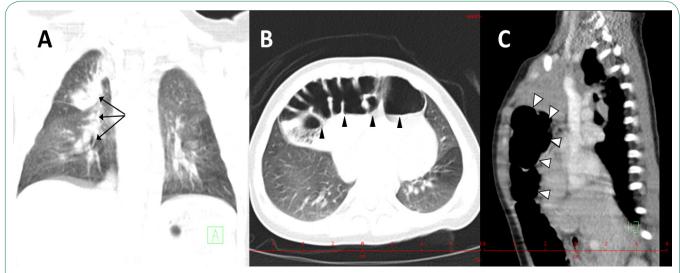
Chest CT of the 7-month-old girl with diaphragmatic hernia and tuberculosis.
